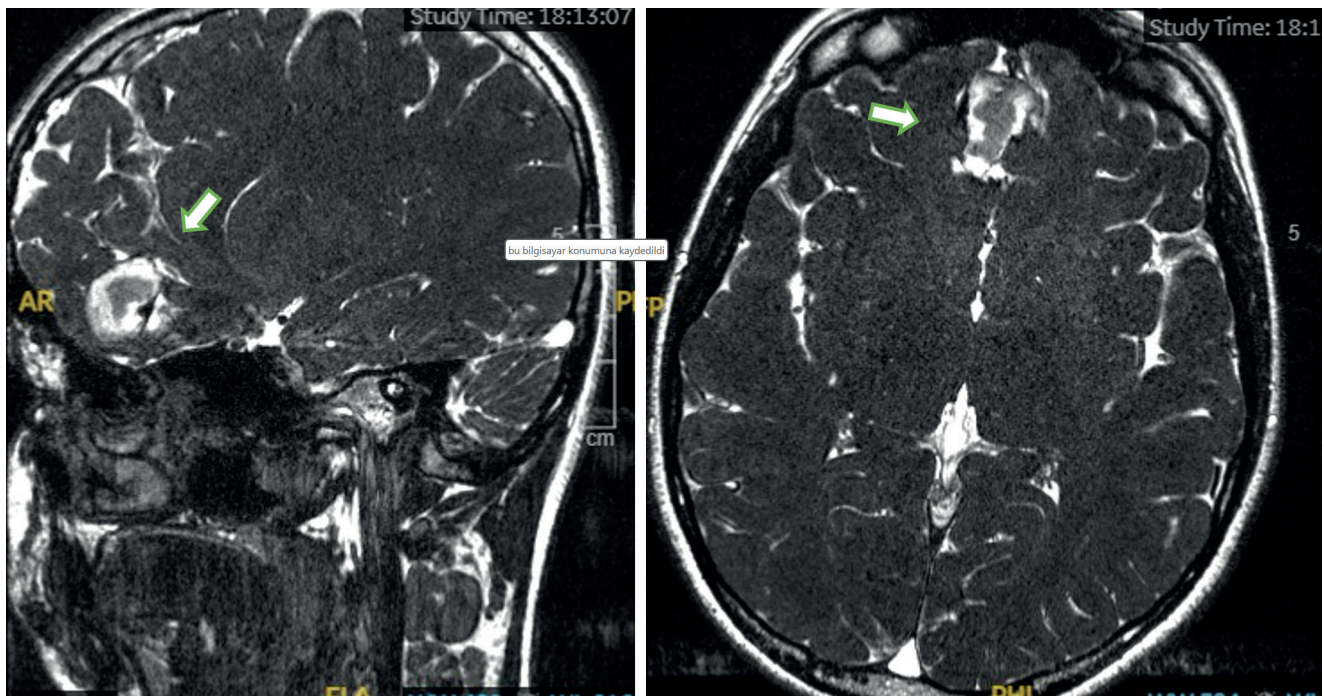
T2-weighted MRI images of a Type III nasal dermoid cyst
